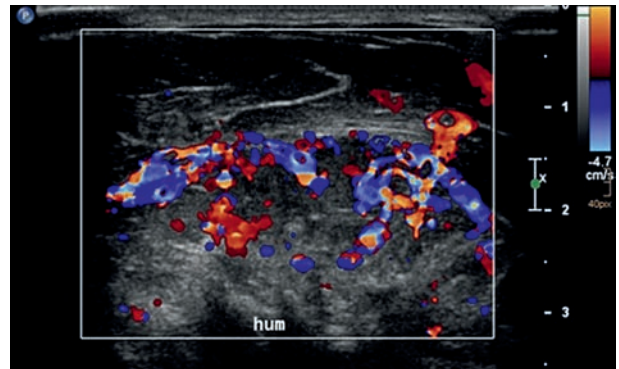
Color-Doppler ultrasound shows a highly vascularized lesion with inhomogeneous distribution of tumor vessels.
